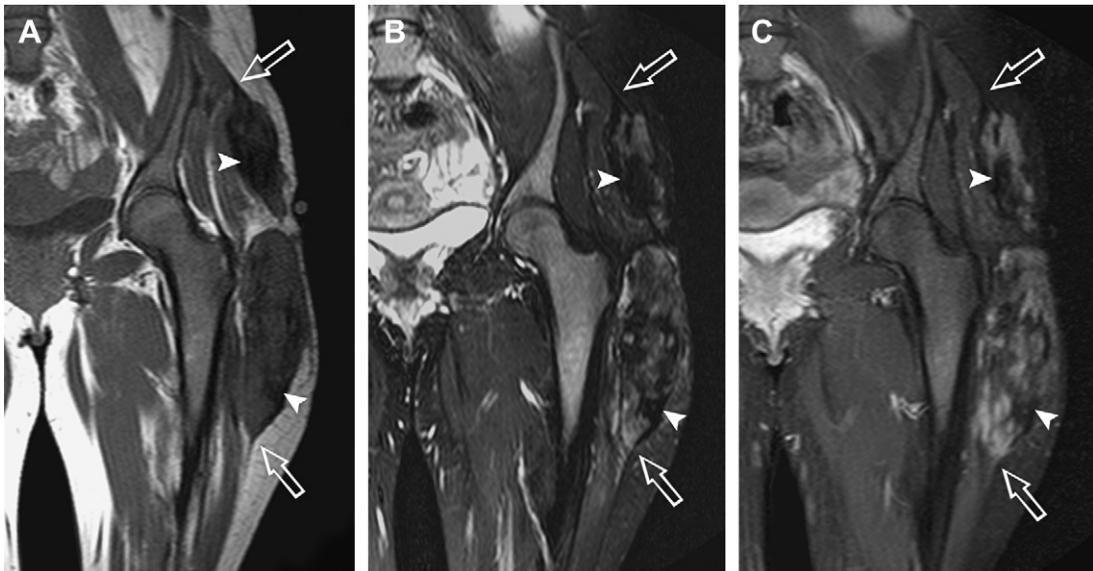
Deep fibromatosis. Deep fibromatosis in a 31-year-old woman with a slowly enlarging thigh mass. (A) Coronal T1W (TR/echo time [TR/TE], 500/15), (B) T2W fat-suppressed (TR/TE, 500/15), and (C) T1W postcontrast fat-suppressed (TR/TE, 4800/70) MR images demonstrate a bilobed heterogeneous thigh mass with intermediate T1 and intermediate T2 signal, with diffuse patchy enhancement. Fascial linear extension can be seen at the proximal and distal aspect (arrows). Areas of bandlike nonenhancing low T1 and T2 signal correspond with hypocellular areas of collagen (arrowheads).
